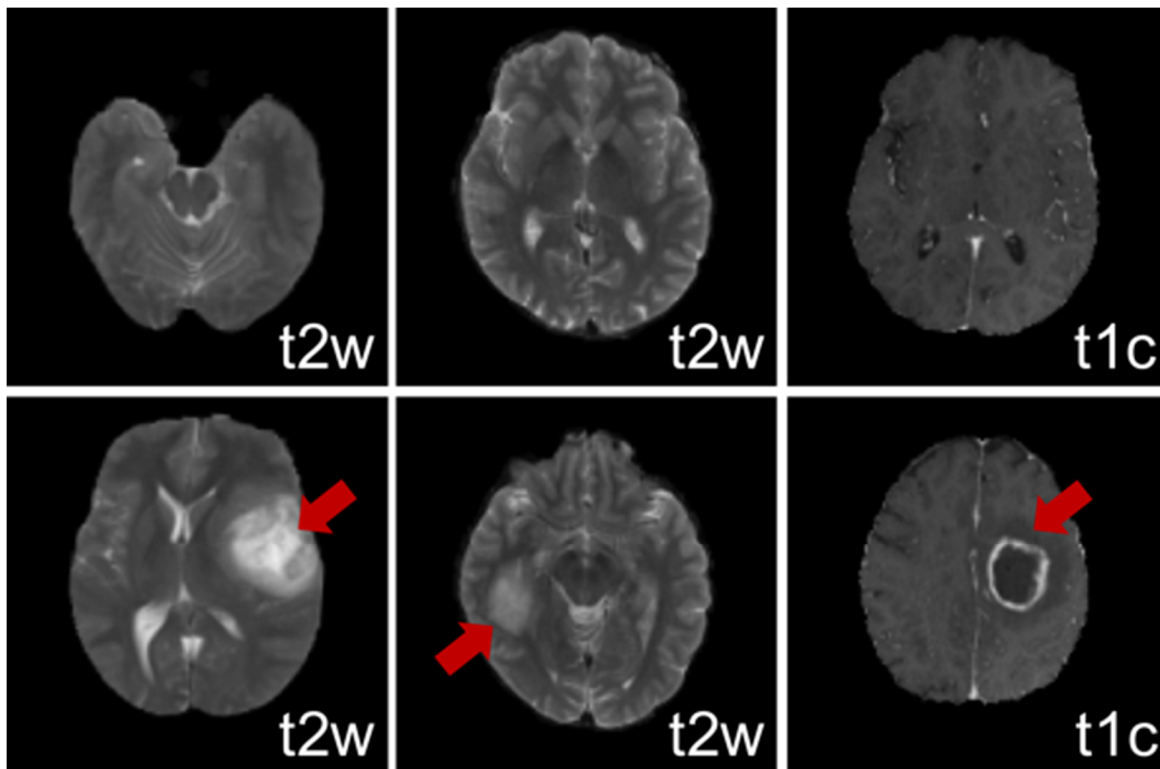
Top row: Three transaxial MR image slices at different levels – two are T2-weighted (T2W) and one is a T1-post contrast (T1c) from three brains. Bottom row: three transaxial images slices showing primary brain tumors (two T2W, one T1c) showing the differences in texture, size and shape.
